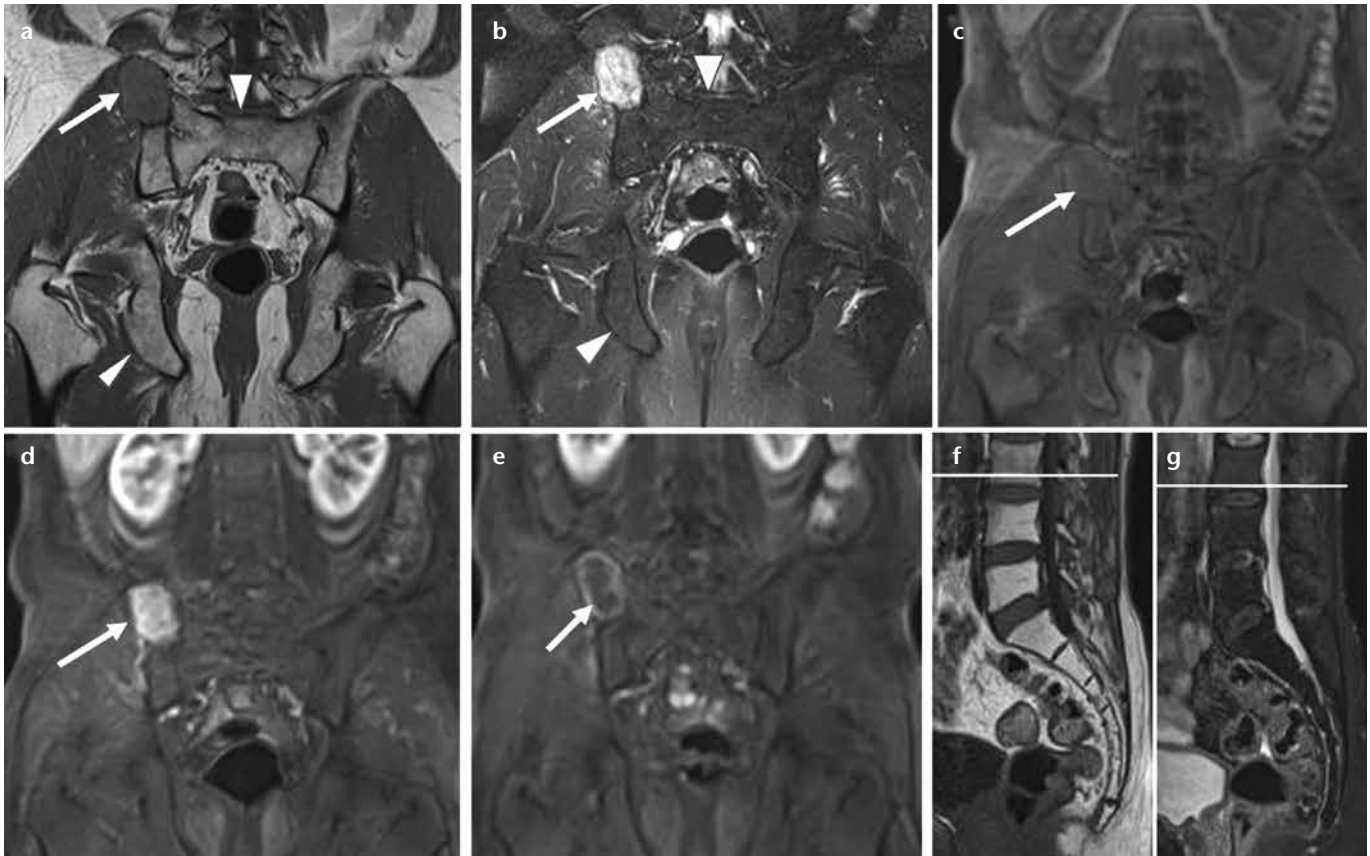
a–g. Fatty conversion following therapy in a 57-year-old male with multiple myeloma in the right iliac bone. Before chemotherapy and radiation therapy, the coronal T1-weighted image (a) depicted the lesion as a hypointense oval mass (arrow), and the coronal T2-weighted fat-saturated image (b) showed a hyperintense mass (arrow). Note the normal signal intensity of the sacral and pelvic bones, both of which show heterogeneous hyperintensity on the T1-weighted image (a, arrowheads) and hypointensity (b, arrowheads) on the T2-weighted image. On the diffusion-weighted image, the lesion is hyperintense on low- and high b images, and the diffusion is restricted (not shown). The coronal T1-weighted fat-saturated images before (c) and after (d) contrast administration show strong enhancement of the lesion (arrows). After chemotherapy and radiotherapy, the coronal T1-weighted fat-saturated image (e) of the myeloma lesion does not show enhancement on the contrast-enhanced image (arrow) and is no longer hypercellular; i.e., it is hyperintense on low b and hypointense on high b, with nonrestricted diffusion (not shown). The sagittal T1-weighted image (f) shows the bone marrow of the L4 and L5 vertebrae, as well as the sacroiliac bones with homogeneous hyperintensity, and the sagittal fat-saturated T2-weighted image (g) shows homogeneous hypointensity. These findings represent post-therapeutic fatty conversion of the bone marrow.
